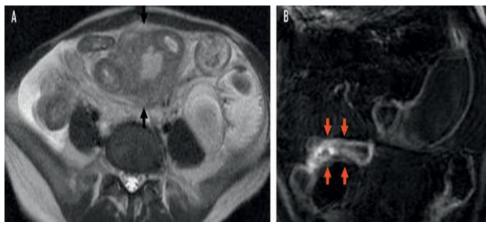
(A) *Phlegmon* appearance (black arrow) on abdominal CT in severe Crohn's disease. (B) Bowel wall thickening (orange arrow) with changes in perienteric fat density in Crohn's disease (Feuerstein and Cheifetz, 2017).
